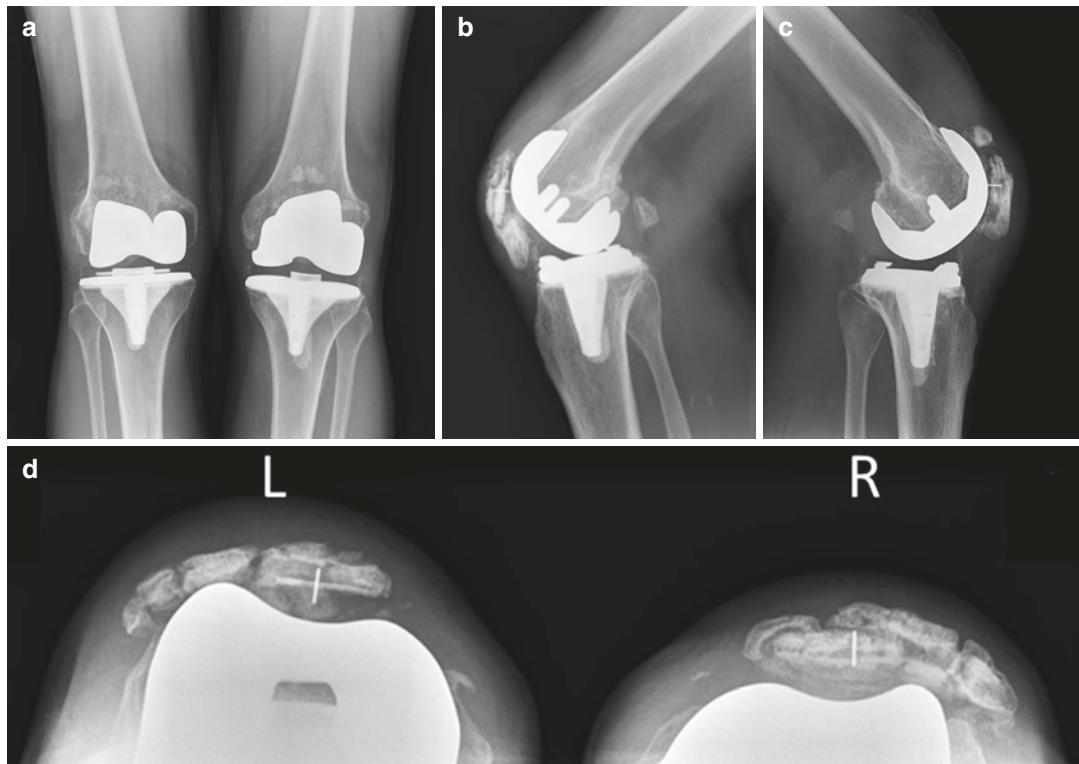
(a) Anteroposterior (AP) radiograph of both knees demonstrates well-aligned CR TKAs. (b) Lateral view of the right knee demonstrates patellar component loosening and patella infera. (c) Lateral view of the left
